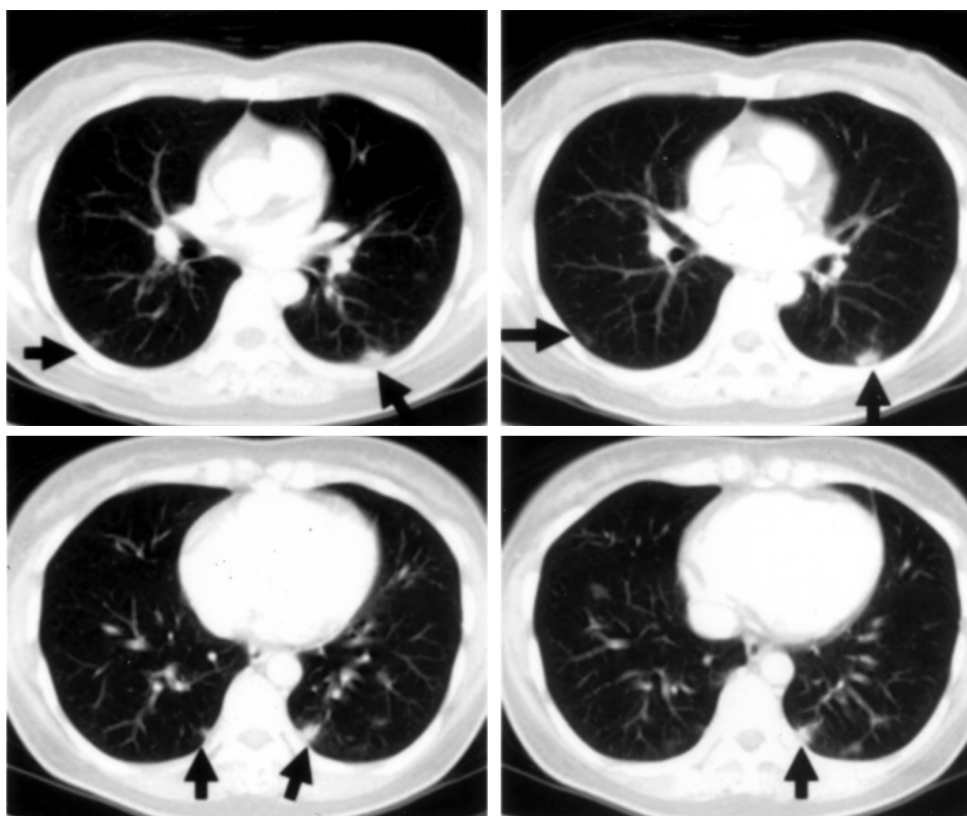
Chest CT revealed some tiny nodules in the LLL and RLL (arrow)
